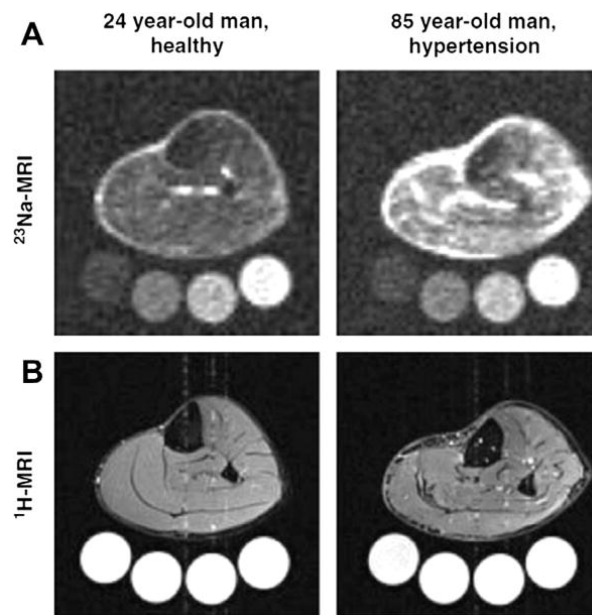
Hypertension imaging example of a healthy and hypertension patient: a) ^{23}Na MR image and b) corresponding ^1H MR image
